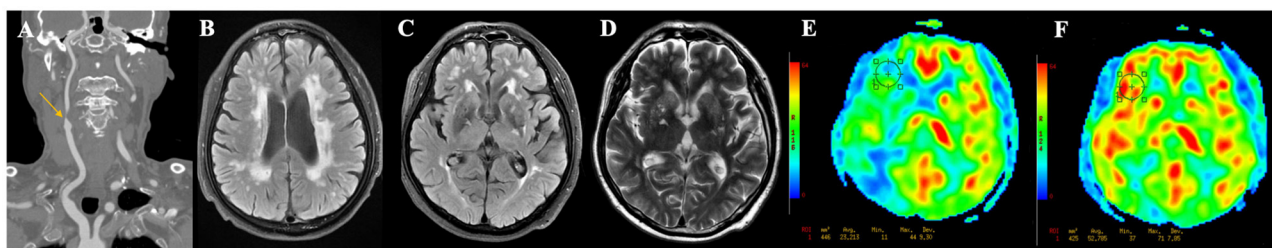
A representative case of cerebral hyperperfusion. (A) Pre-operative computed tomography angiography shows severe stenosis of the right carotid artery. (B–D) Pre-operative T2WI and FLAIR show severe white matter hyperintensities (Fazekas score = 6), multiple lacunes in bilateral basal ganglia, and category-3 perivascular spaces. (E) Pre-operative arterial spin labeling image shows a significantly decreased cerebral blood flow (23.21 ml/100 g/min) in the watershed area. (F) Post-operative arterial spin labeling image shows the cerebral blood flow (52.79 ml/100 g/min) increase >100% compared with pre-operative values.
